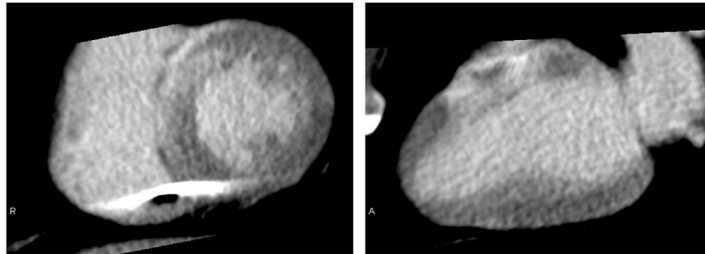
LE in a patient with cardiac sarcoidosis assessed using (A) LGE-MRI before pacemaker placement, and (B) CT-LE after placement. Epicardial LE was revealed in the antero-septal wall on LGE-MRI, and this finding is also well visualized by CT-LE despite the presence of metal artifact from the pacemaker leads in the inferior wall. LGE, late gadolinium enhancement; MRI, magnetic resonance imaging; CT-LE, computed tomography late enhancement; LE, late enhancement; CT, computed tomography.
